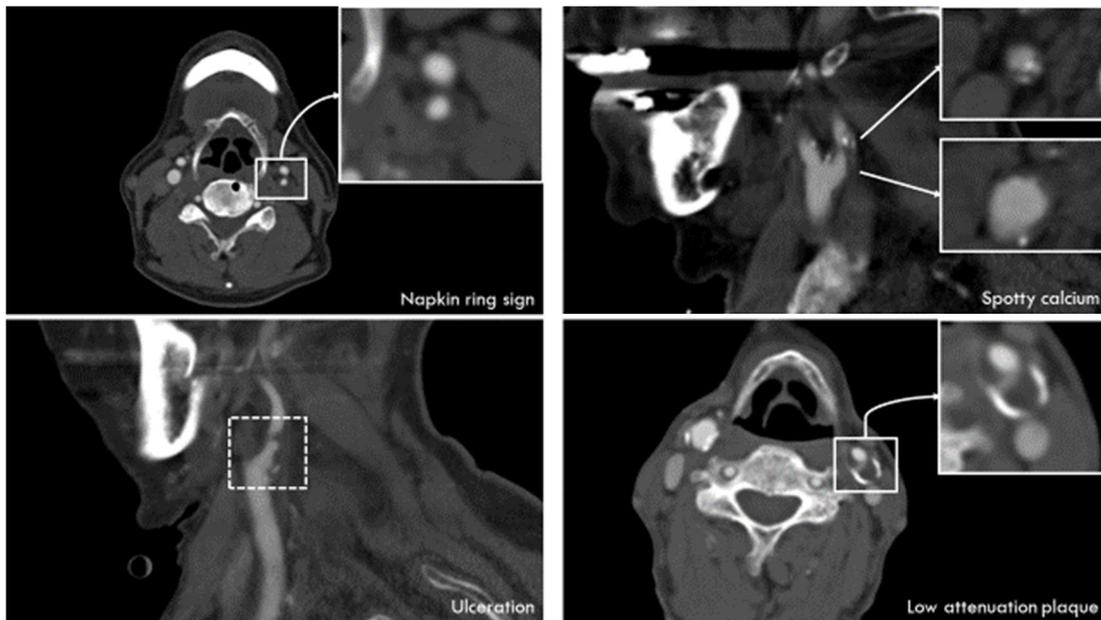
High-risk features of carotid plaque on CTA
